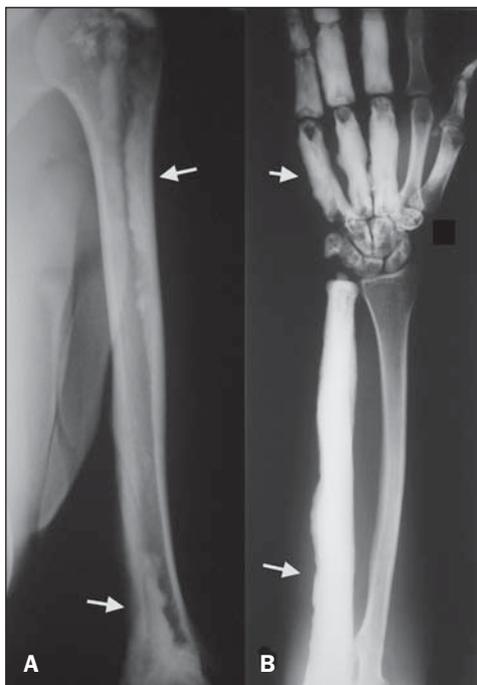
Radiographic images of left arm (A), forearm and hand (B) demonstrating cortical hyperostosis along the bone axis resembling “melted candle wax” (arrows).
